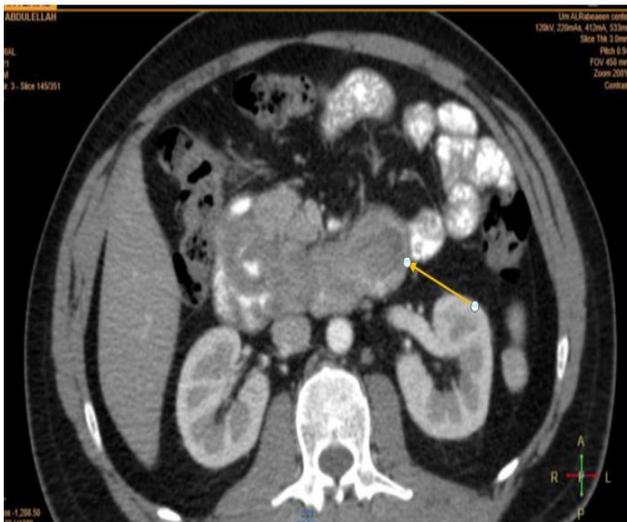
CT abdomen with contrast also showed a hypodense intraluminal filling defect (11x4.5cm) involve the 1st and 2nd part of duodenum (arrow) that enhanced post contrast with stalk like extension.
